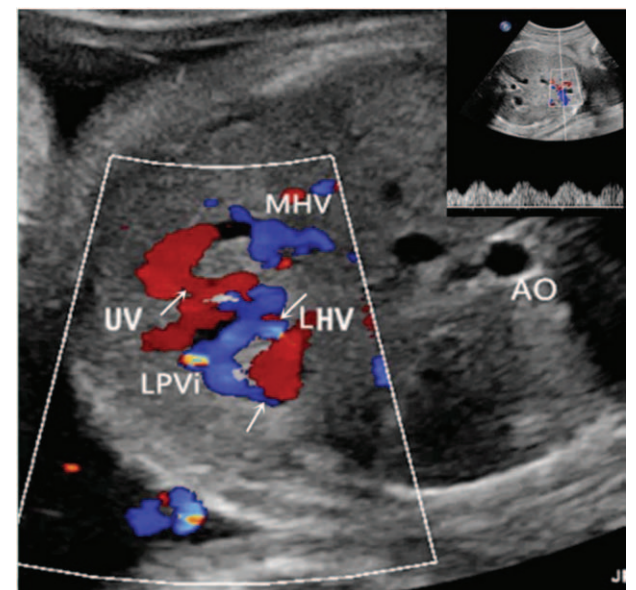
A representative sonogram of case 8. A transverse scan shows a shunt (arrow) between the LPV1 and LHV. LHV was enlarged and triphasic waveforms were detected at the shunt site (inserted at the right-upper corner). AO=aorta, LHV=the left hepatic vein, LPV1=inferior branch of the left portal vein, LPVs=superior branch of the left portal vein, SP=spine.
